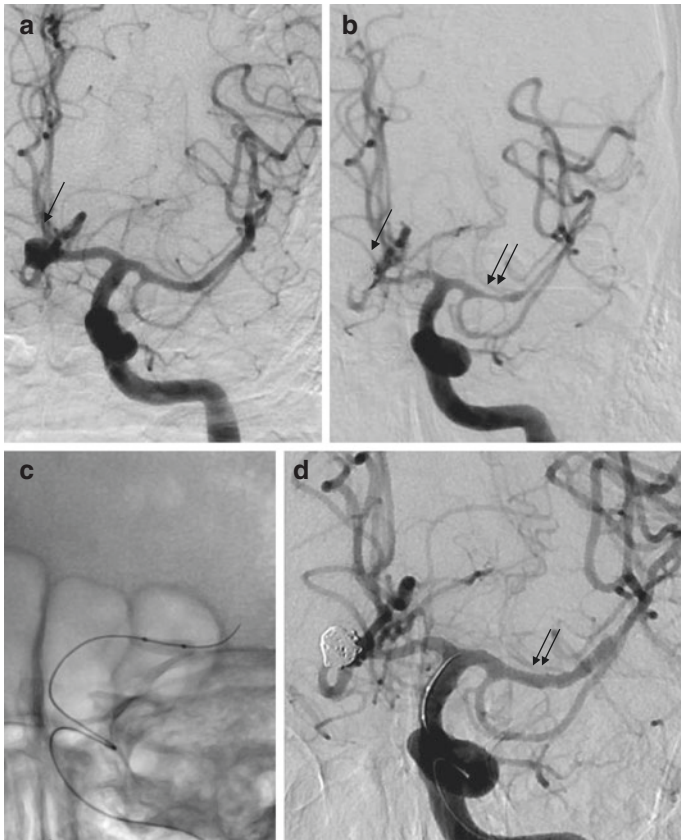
This 53-year-old man presented with a sudden-onset, severe headache. A CT head demonstrated a starburst pattern of subarachnoid hemorrhage. (a) A diagnostic cerebral angiogram (DCA, left internal carotid artery (ICA) injection, AP view) demonstrates an AComA aneurysm (arrow). He underwent endovascular coiling of the ruptured aneurysm the next day. (b) On post-SAH day #5, he developed new-onset R-sided weakness and word-finding difficulty. These did not improve with a trial of induced hypertension. A DCA demonstrates the coiled AComA aneurysm (arrow) and interval development of moderate-to-severe vasospasm of the L MCA (double arrow). (c) Balloon angioplasty of the L MCA is demonstrated with an excellent angiographic result (double arrow) (d). His R-sided weakness and aphasia resolved in short course
